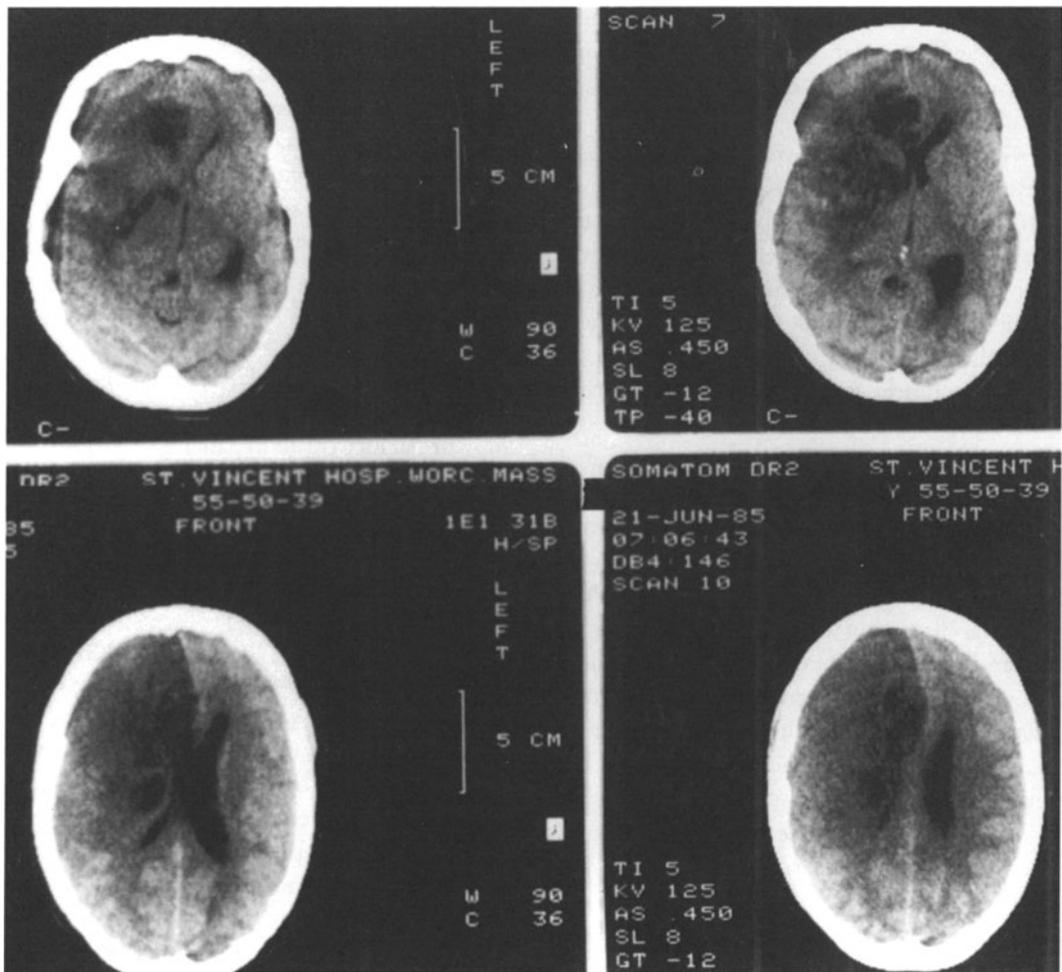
Combined infarction ACA and MCA territories related to severe stenosis of supraclinoid, internal carotid artery and proximal (M1) segment of MCA, with infarction territories of right anterior and middle cerebral arteries. CT scan. Case 26-1. Refer to text.
